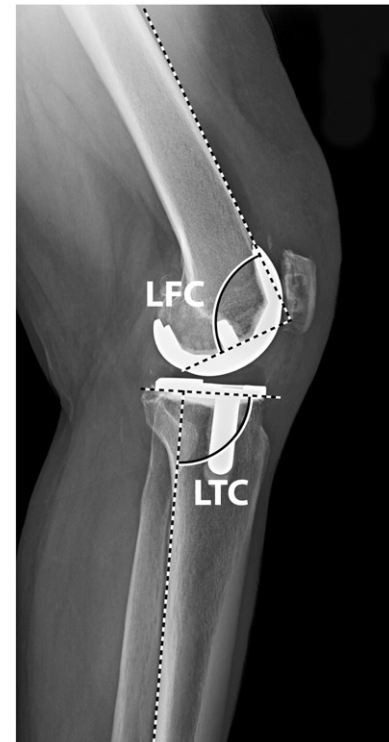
Standard lateral radiograph shows the femoral component flexion, measured as the lateral femoral component angle (LFC) and tibial component posterior slope, measured as the lateral tibial component (LTC) angle.
